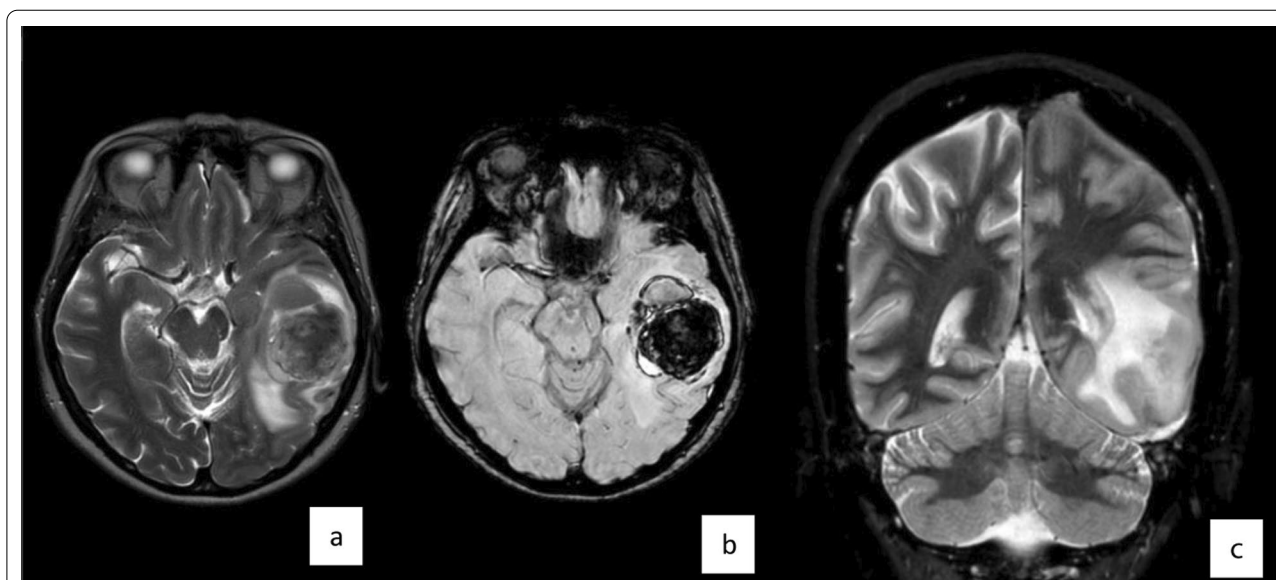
The non-enhancing brain MRI: a axial T2 showed isointense of the left temporal lobe surrounded by hyperintense edema and medium structures dislocation; b axial SWI showed hypointense lesion in the left temporal lobe; c coronal T2 showed two subdural hematomas, left hemisphere edema
